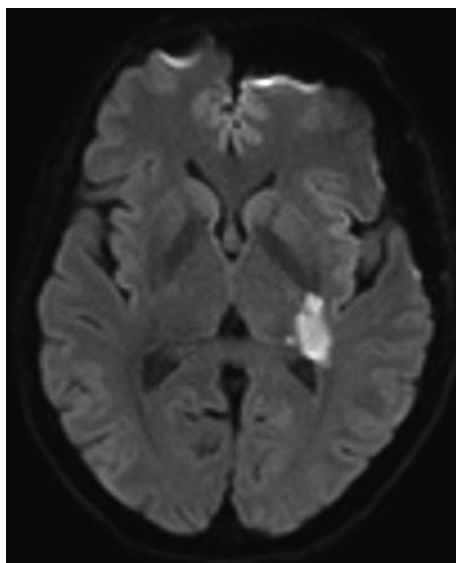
Diffusion-weighted magnetic resonance imaging axial view in patient 6 1 day after surgery showing an acute ischemic left thalamocapsular lesion responsible for a right-sided hemianopia and mild hemiparesis.
